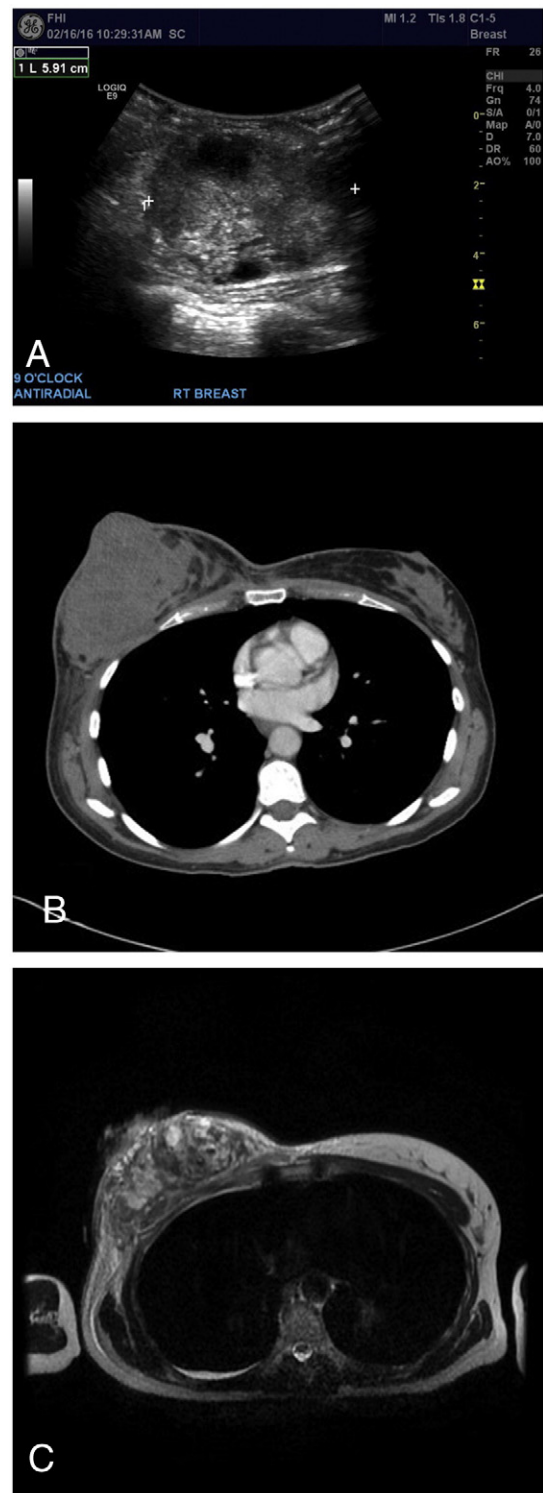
Imaging of the right breast. A, Ultrasonography showing heterogeneous, partially cystic mass. B, Chest computed tomography scan showing the heterogeneous mass. C, Magnetic resonance imaging of the chest showing the mass with skin and pectoralis major muscle involvement.
